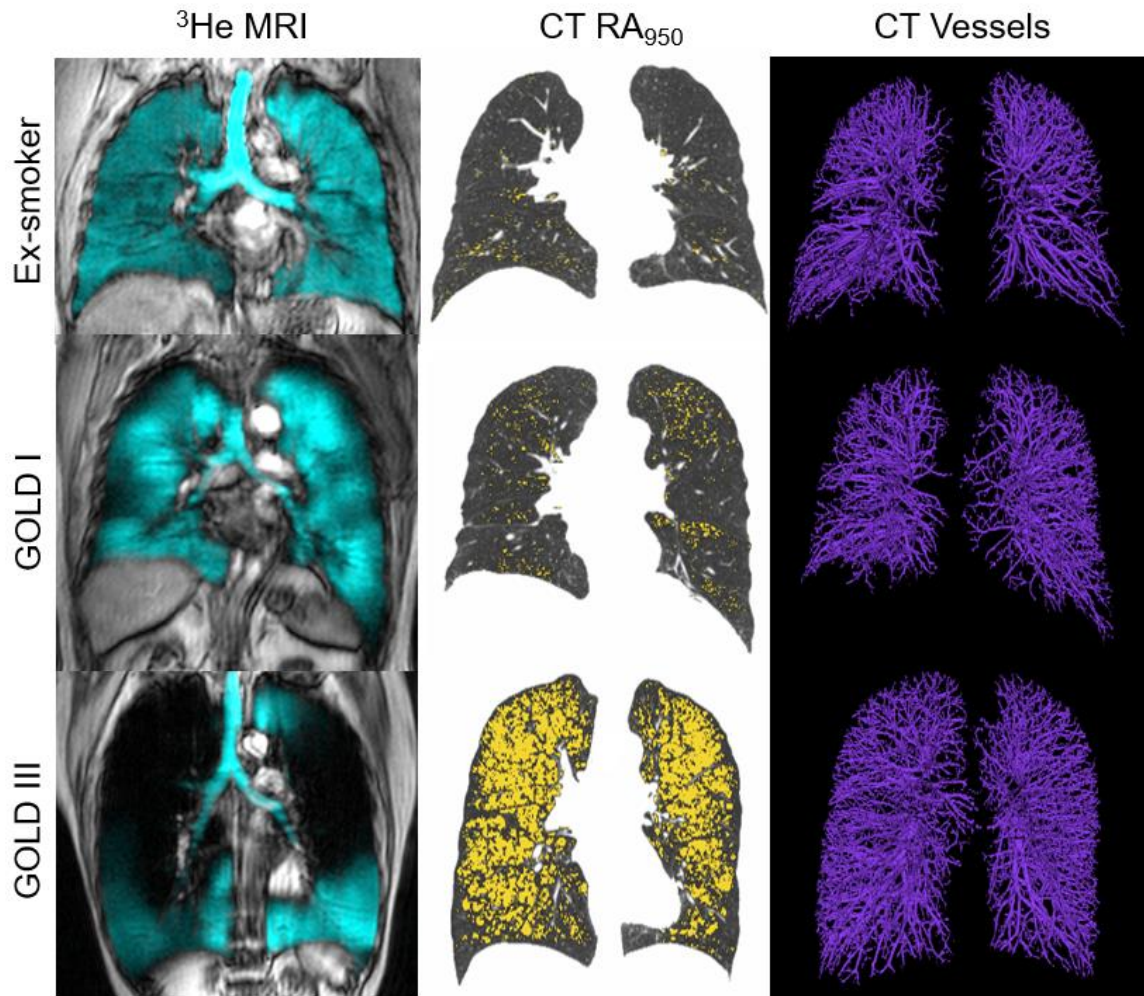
Baseline MR and CT images for representative ex-smoker without COPD and representative participant III COPD.
